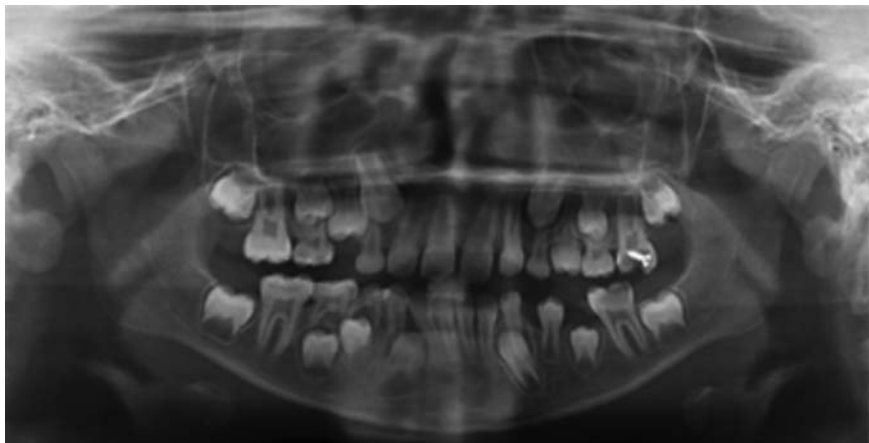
Orthopantomogram showing a well-defined radiopaque foreign object in the tooth.
